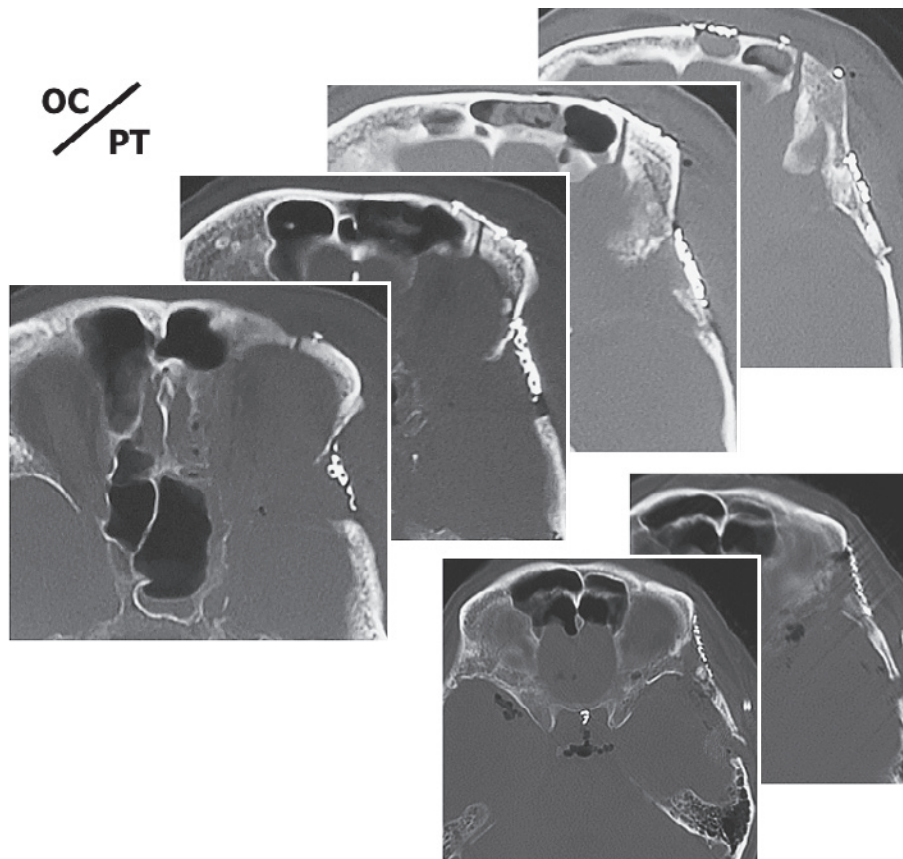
Postoperative bone window computed tomographic imaging. Orbitocranial approach (upper left) and pterional approach (lower right).
